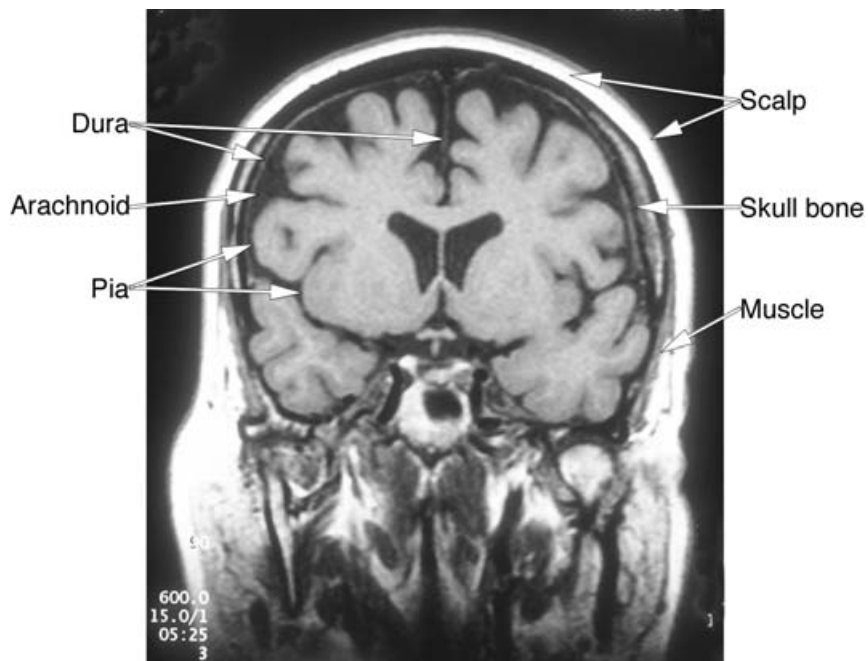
Coverings of the brain on MRI scan.
